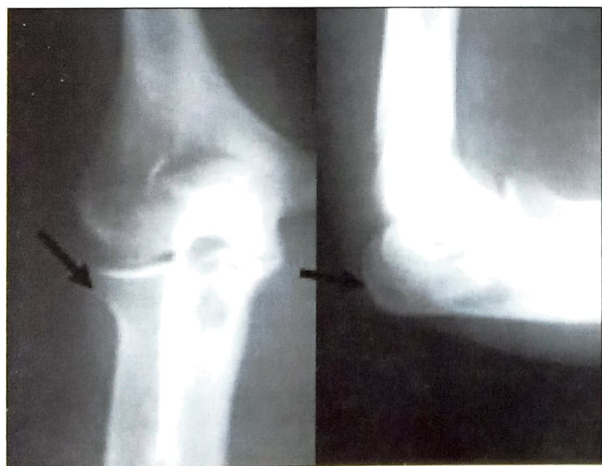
X-Ray Right Elbow Showing Lytic Lesion In Upper End Of Radius.
